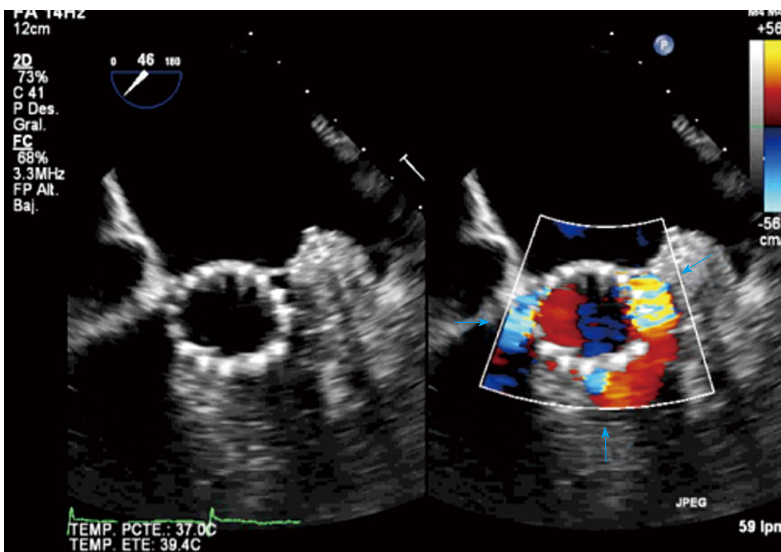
Transesophageal echocardiography at 46° without and with color Doppler showing 3 paravalvular leaks (arrows) after valve implantation.
